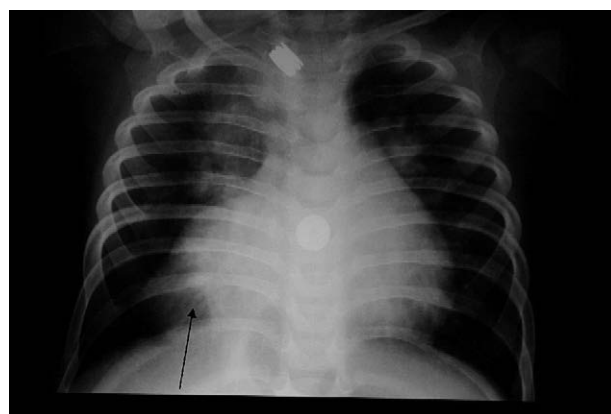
Posterior-anterior chest radiograph shows right pericardial opacity suggesting a partial elevation of the right diaphragmatic leaflet.
